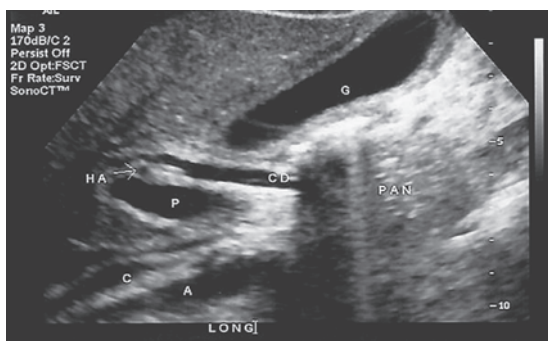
Normal common bile duct. Sagittal sonogram shows the portal vein (P) and the common bile duct (CD) anteriorly. HA—hepatic artery, C—inferior vena cava, A—aorta, PAN—head of pancreas, G—gallbladder.
